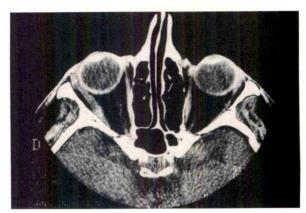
(Disdier and associates). Computed tomographic scan of the orbits showing thickened right lateral rectus muscle.
